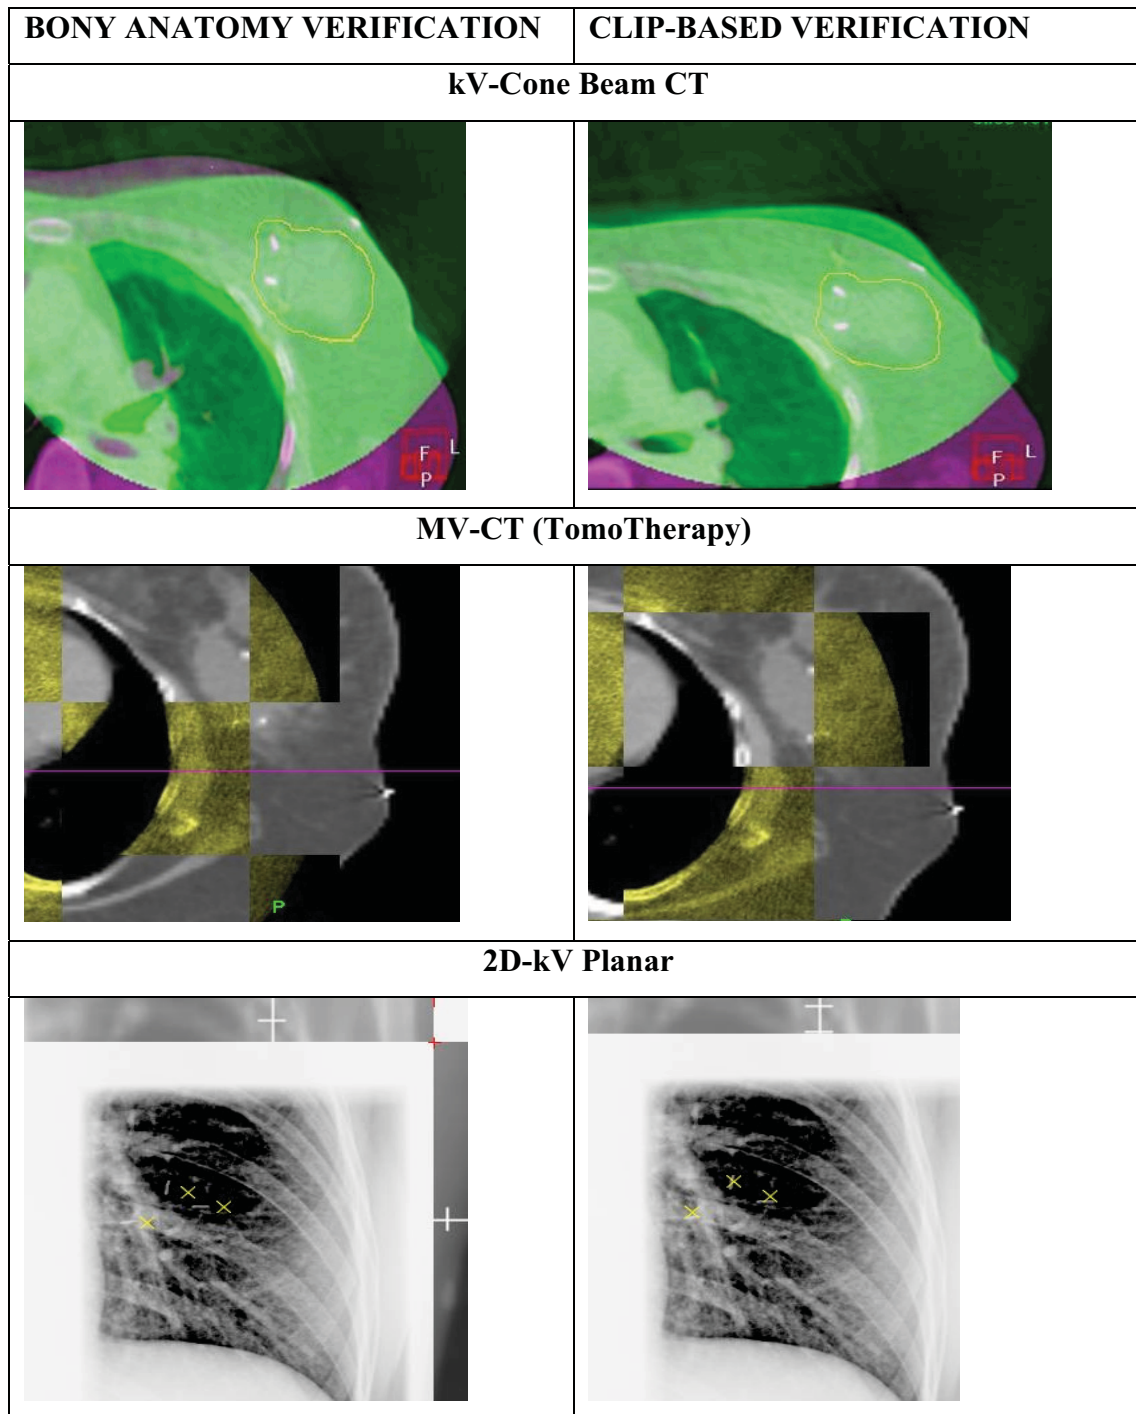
Bony anatomy and clip-based verification using kV-CBCT, MV-CT and 2D-kVPI.
